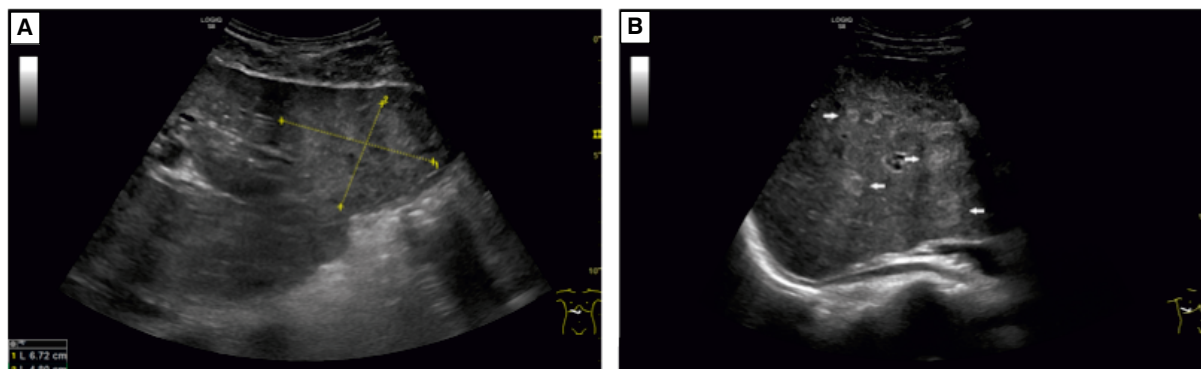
A. Ultrasound image of a large hyperechoic lesion in the left lobe (marked and measured); B. ultrasound image of hyperechoic lesions in the liver (the largest ones marked with white arrows)
